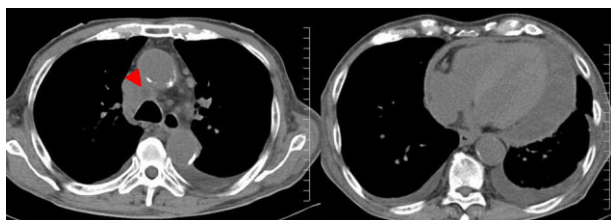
Thirteen days after endobronchial ultrasound-guided transbronchial needle aspiration, chest computed tomography showed swelling of the 4R lymph node, elevation of mediastinal fat concentration (arrow), and a moderate pericardial effusion.
